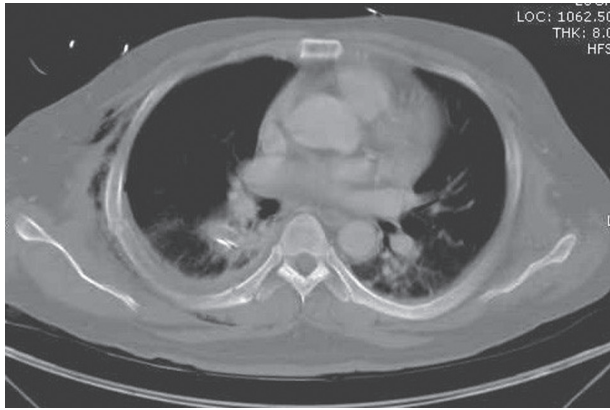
Chest computed tomography (CT) scan showing bilateral alveolar infiltrates suggesting pulmonary contusion. There are also multiple rib fractures and subcutaneous emphysema.
